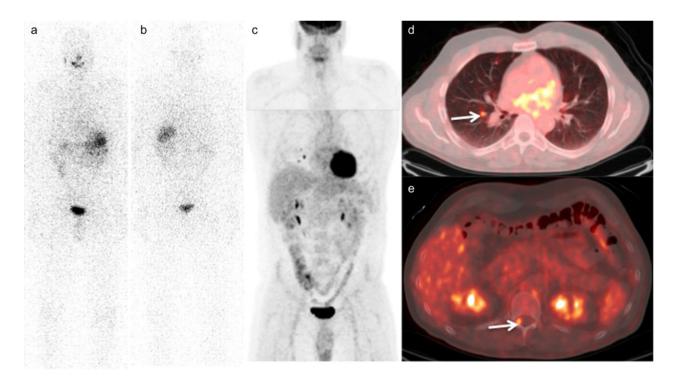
Positive follow-up PET/CT and outcome: anterior (a) and posterior (b) planar radioiodine scintigraphy, anterior maximum intensity projection(c), axial fused PET/CT (d, e) images of a 50-year-old man with follicular thyroid cancer who underwent follow-up imaging 5 years after completion of treatment with elevated thyroglobulin. The radioiodine scintigraphy images show a negative study, and the PET/CT study demonstrates increase FDG uptake within multiple pulmonary nodules and the lamina of T12 vertebra, consistent with metastatic disease. Despite treatment, the disease progressed resulting in death 3 years after the study.
